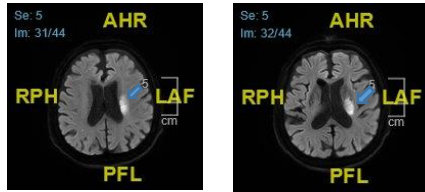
Brain MRI diffusion: Cerebral infarction on left corona-radiata.
